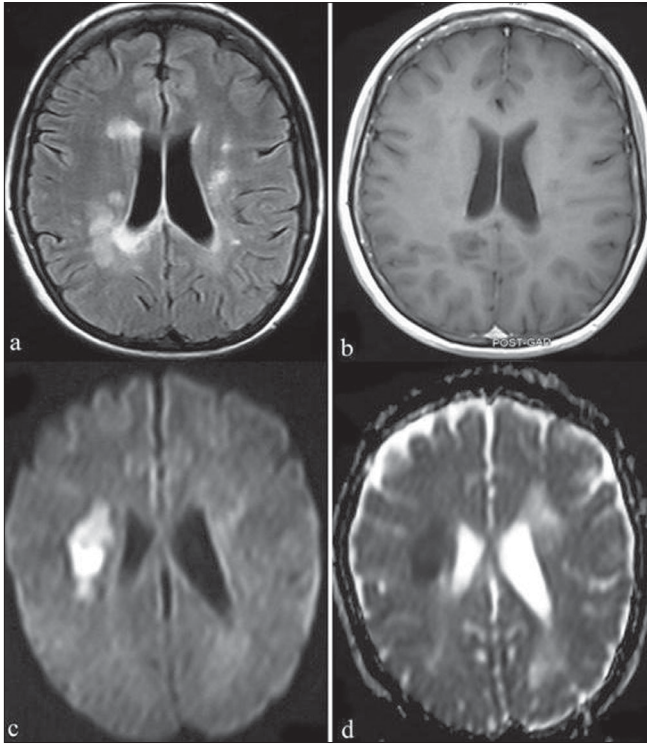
Multiple sclerosis. Axial FLAIR (a) image shows multiple round-ovoid juxtaventricular hyperintense lesions perpendicular to the ventricular surface. None of these lesions shows enhancement following intravenous gadolinium administration (b). Diffusion-weighted image (c) and ADC map (d) show restricted diffusion in one of the lesions in the right corona radiata, suggesting cytotoxic edema in an acute demyelinating lesion
